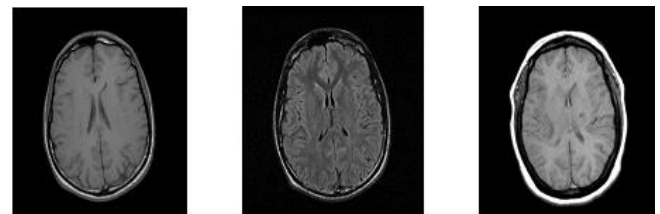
Normal brain CT images.
